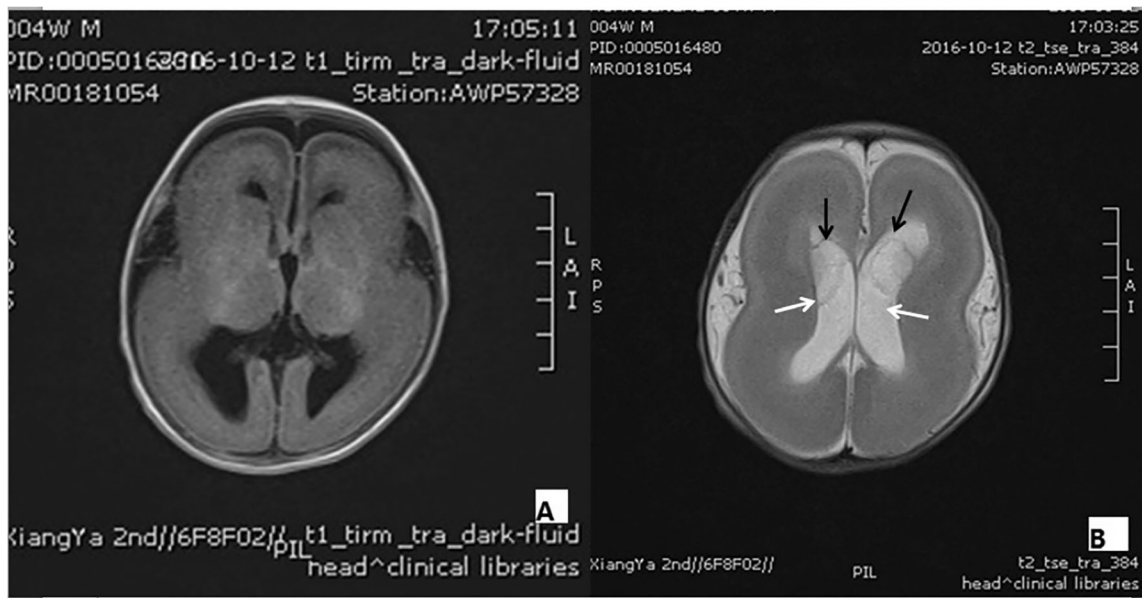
MRI of the 25-day-old male baby with lissencephaly. a There is an overall immature sulcation pattern with thickening of the cortex compatible with lissencephaly generalized throughout the brain.
